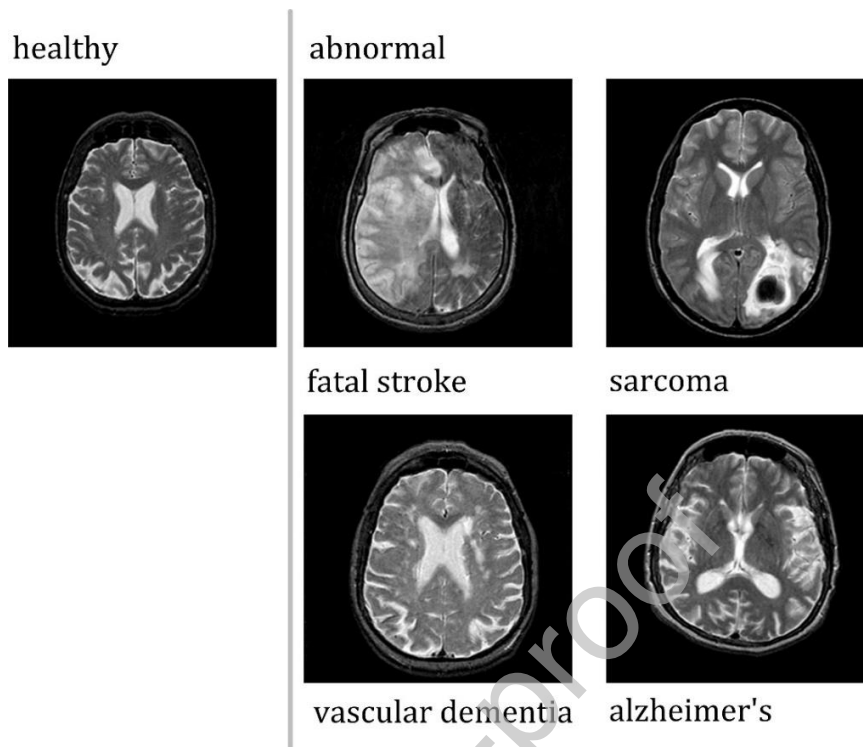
Sample MRI-T2 images from Harvard Medical School.
